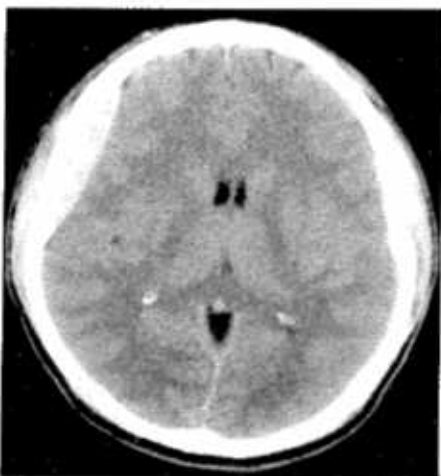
CT scan of chronic bilateral subdural hematomas of different ages. The collections began as acute hematomas and have become hypodense in comparison to the adjacent brain after a period during which they were isodense and difficult to appreciate. Some areas of resolving blood are contained on the more recently formed collection on the left (arrows).
